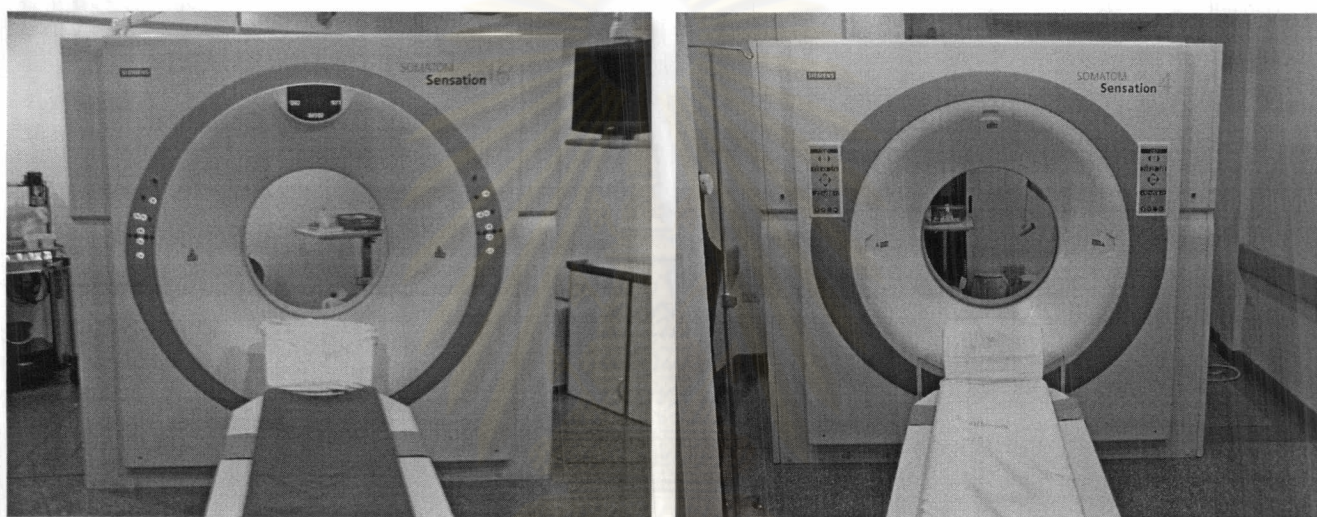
Two types of CT scanners, on the left side is Siemens Sensation 16 and on the right is Siemens Sensation 4 .
